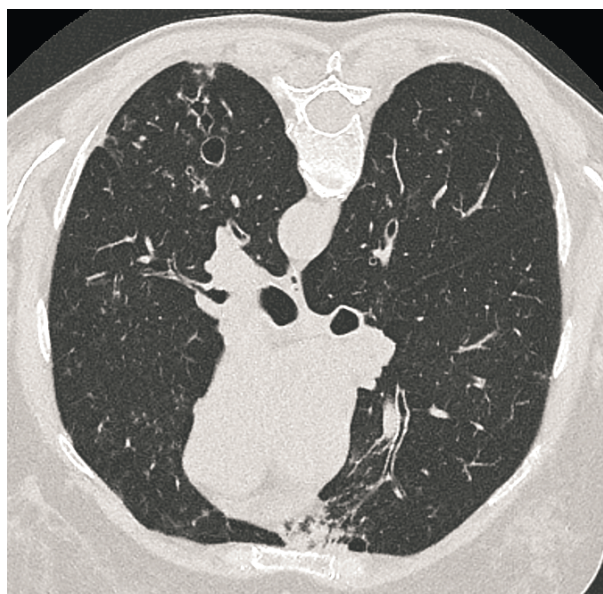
HRCT showing non tapering bronchioles with Signet ring appearance and classic tram track sign appearance of bronchi anteriorly, in keeping with bronchiectasis.
